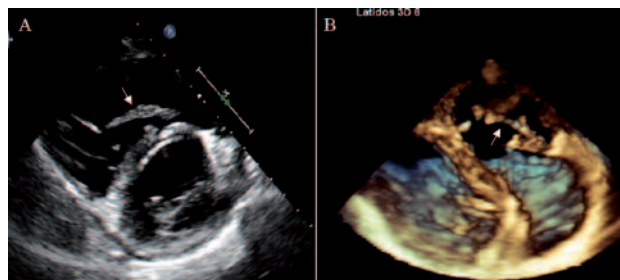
A. Short-axis parasternal view of transthoracic echocardiogram, showing a floating thrombus in a dilated right ventricle. B. In vivo 3D image of the right ventricular outflow tract, showing the thrombus attached to the tricuspid subvalvular apparatus. (arrow).
